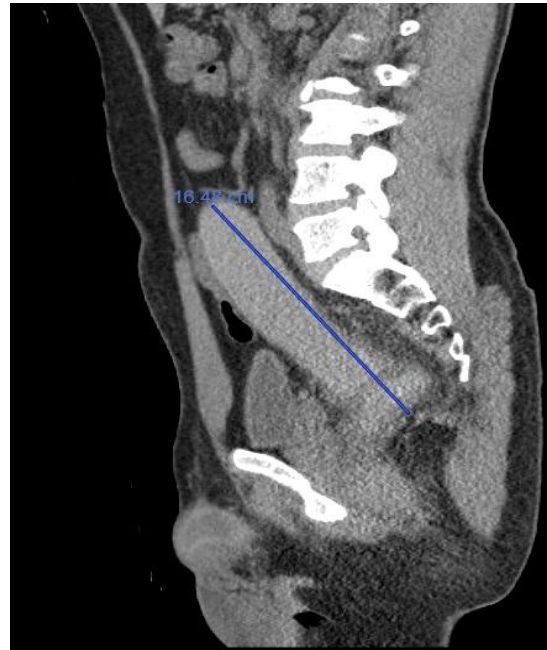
Sagittal CT scan visualizing a retained rubber sex toy after the failure of visualization on plain radiograph.
